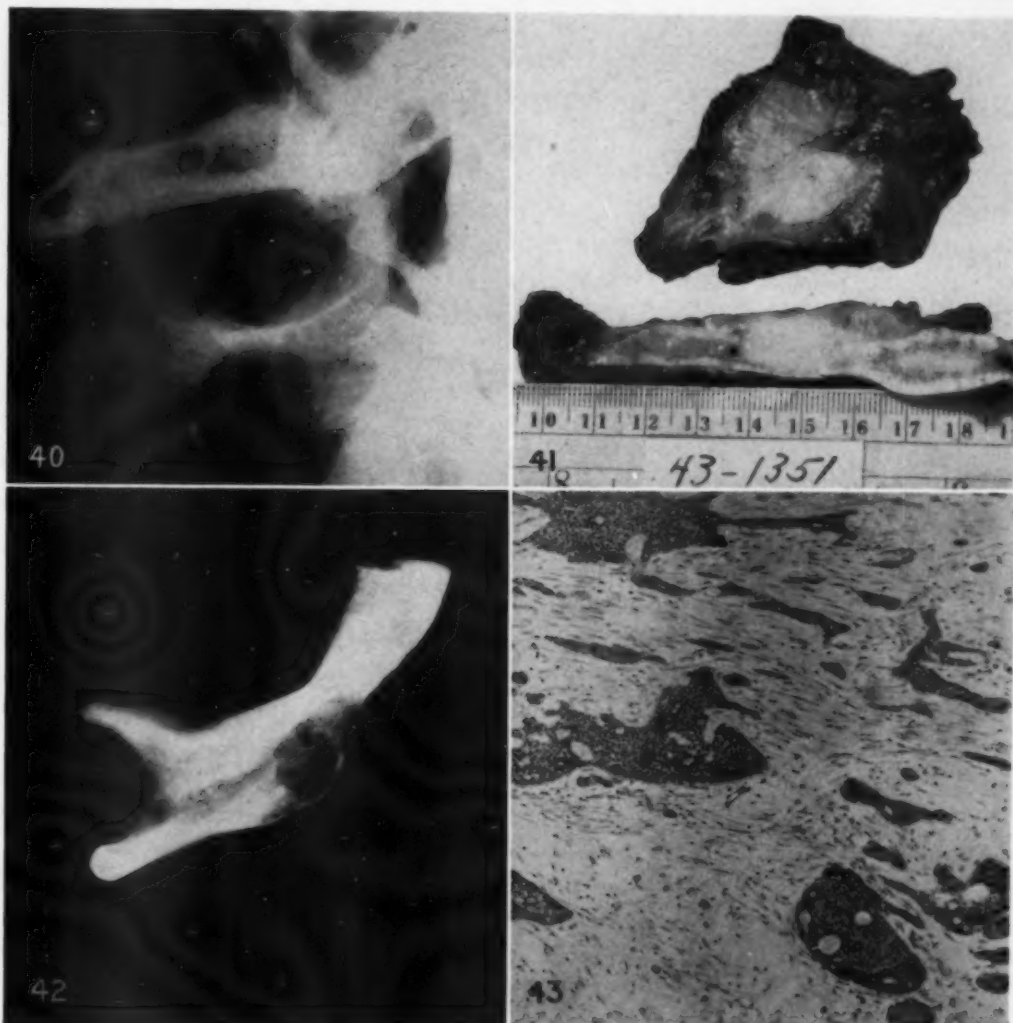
Case 12. Oblique radiograph showing destruction of bone by mixed tumor.
